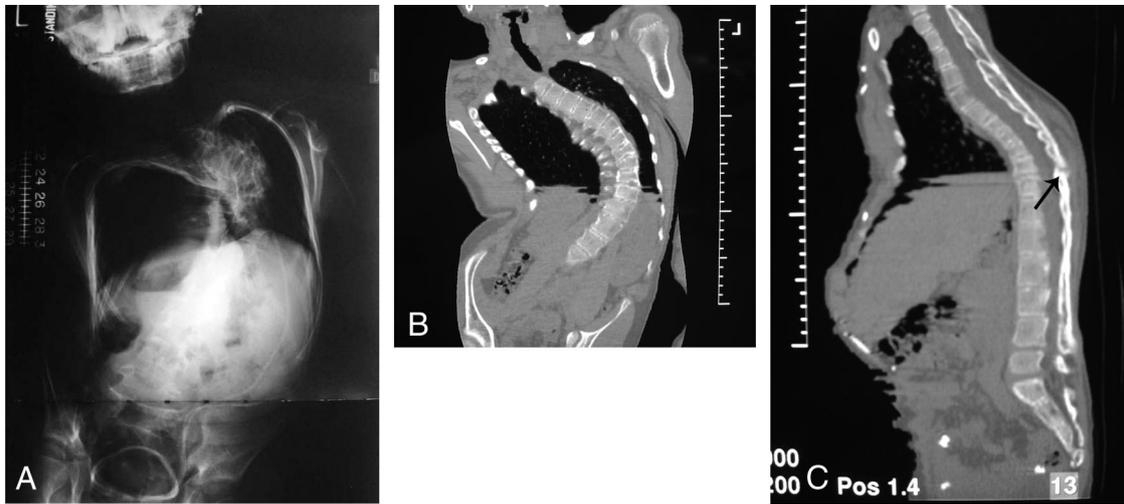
Utility of the CT scan. A, PA radiograph an 11 year-old boy who had multiple previous surgical treatments for spinal deformity. His radiographs are very difficult to visualize to understand his anatomy. B, The multiplanar reconstruction CT image in the coronal plane with greater visualization of the anatomy demonstrating multiple sites of nonunion from the previously-attempted anterior fusion C, The lateral multiplanar reconstruction CT image demonstrating a posterior pseudoarthrosis (arrow).
